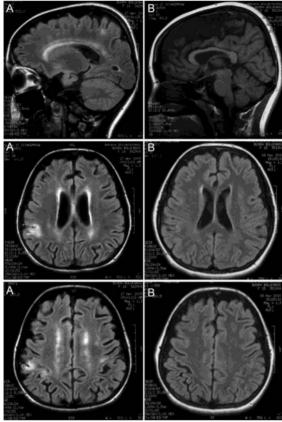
Magnetic resonance imaging (MRI) findings: a. After recurrence of symptoms, and b. After treatment.
